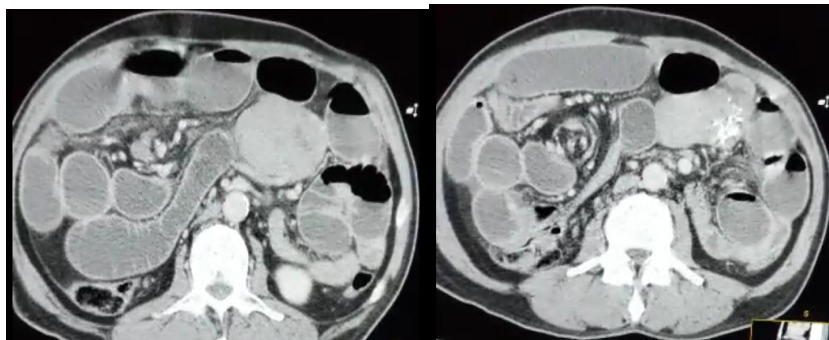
CT scan showing the GIST and the Whirlpool sign
